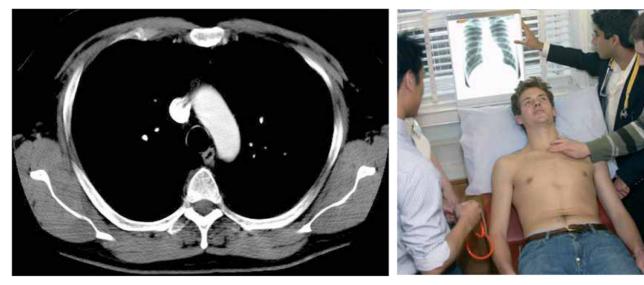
CT Scan of the thorax at vertebral level T4.
